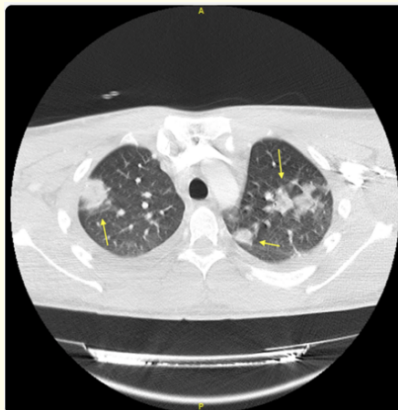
Chest CT. Multiple condensations compatible with septic embolisms (arrows).
